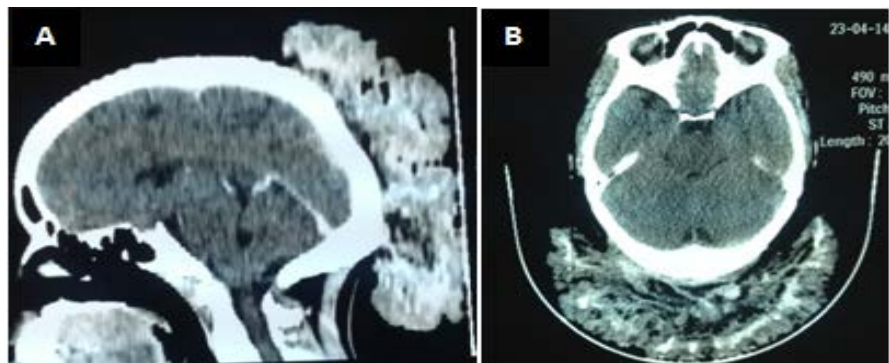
Brain CT showing the heterogenous occipital tumor, Sagittal reconstruction (A) and Axial section (B).
